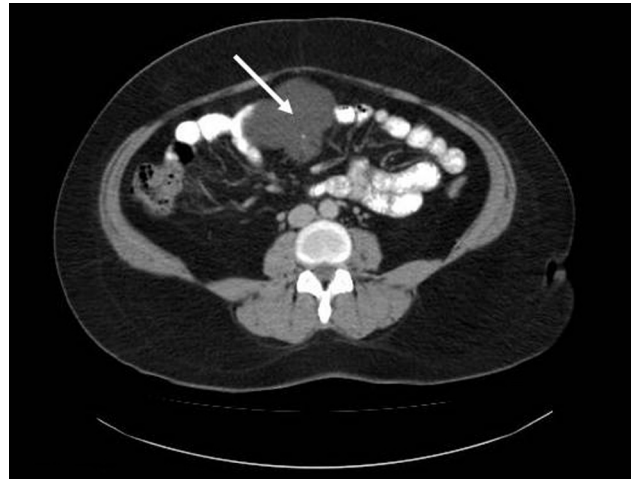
Computed tomography imaging of the abdomen shows a cystic lesion with sharp boundaries and lobular contours in the middle abdominal region between the jejunal loop (arrow).
